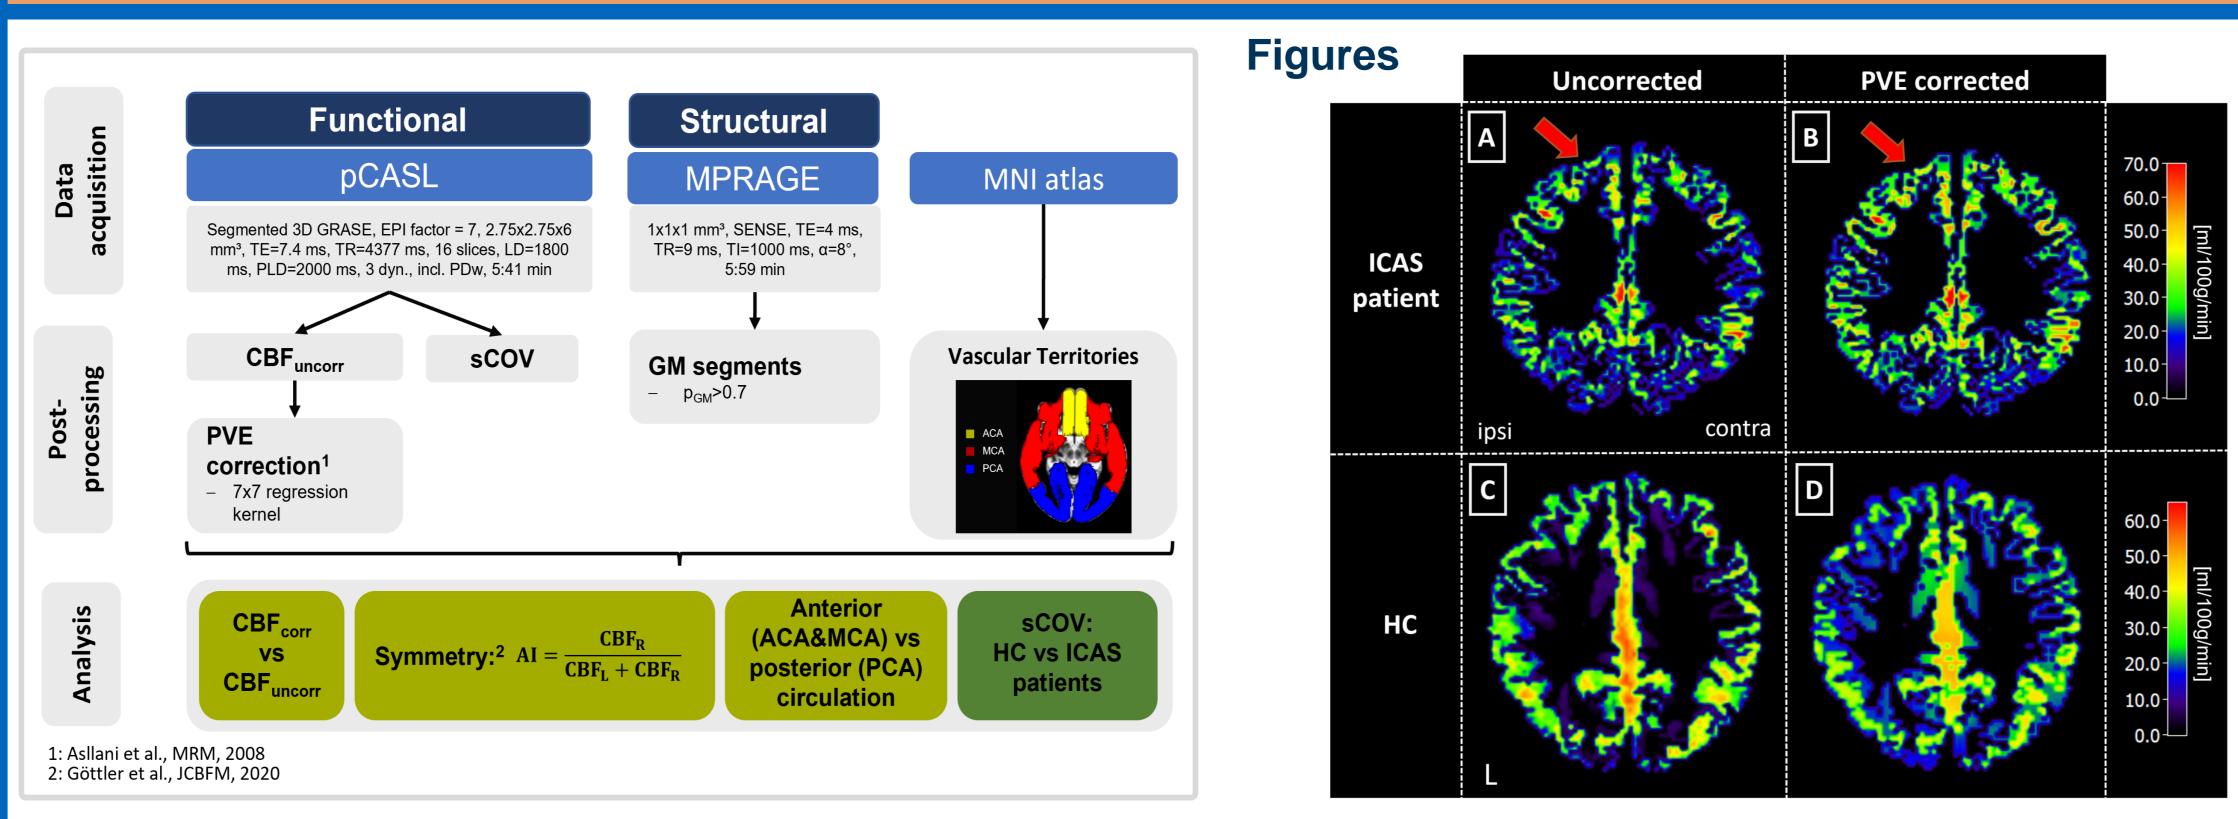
MRI protocol and derived parameters. Perfusion imaging used pCASL. PVE corrected CBF and sCOV were calculated. Vascular perfusion territories were derived using a MNI based atlas. Data analysis of PVE correction was based on global comparison of CBF values, asymmetry indices (AI), percentage perfusion increases across territories. sCOV was compared between healthy controls (HC) and ICAS patients.
